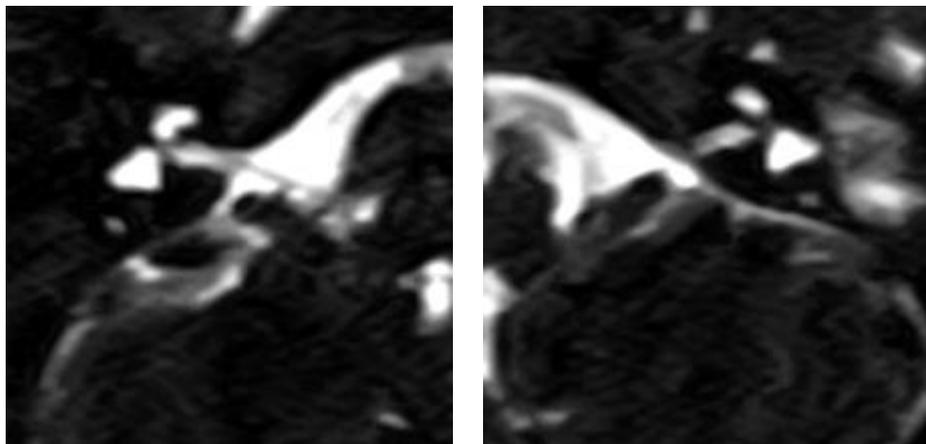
In the same patient, there is absence of the cochlear nerve bilaterally on MRI 3DT2 sequence.
